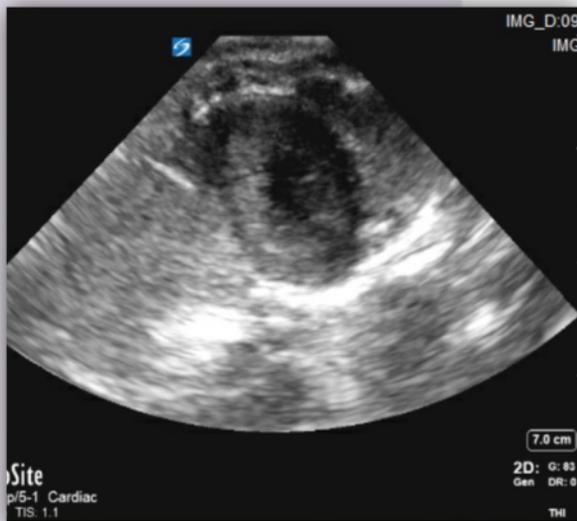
Parasternal short axis view of the heart with mass lying adjacent to left ventricle
